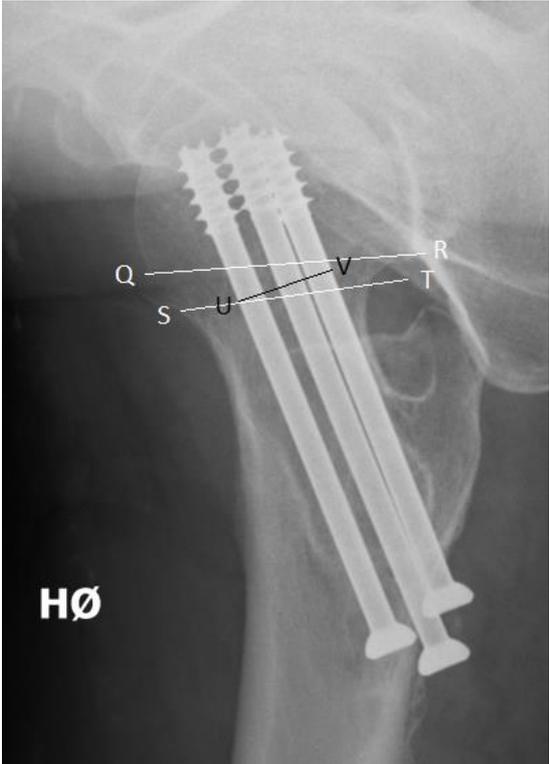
Measurements of distances in the post-surgery x-rays. The fracture area lies between QR and ST. In this area, the spread of the implants is measured as UV.
